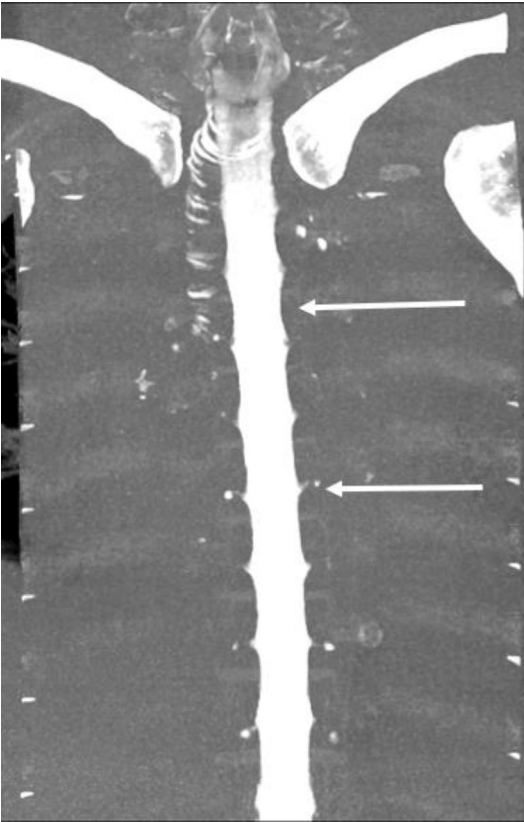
Coronal dual energy CT myelogram with bone subtraction algorithm. Arrows point to the clearly outlined nerve roots of the cauda equina.
